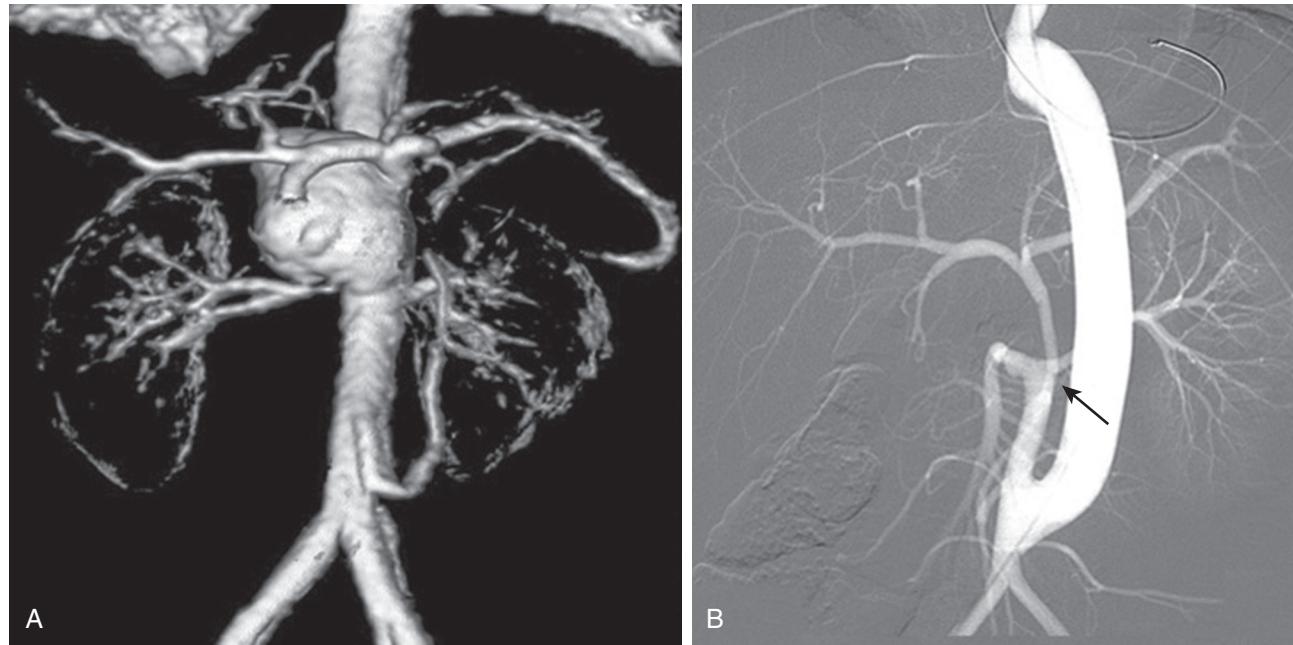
(A) Central abdominal aortic aneurysm with involvement of the celiac, superior mesenteric, and renal arteries associated with tuberous sclerosis in a 5-year-old (computed tomography angiography). (B) Treatment included aneurysmectomy, 14-mm expanded polytetrafluoroethylene thoracoabdominal bypass, aortic reimplantation of a left renal artery and superior mesenteric artery (SMA), and aortoceliac bypass with a hypogastric artery graft, all from the distal abdominal aorta (arrow), as well as a right nephrectomy (digital subtraction arteriography). (From Eliason JL, Coleman DM, Criado E, Stanley JC. Surgical treatment of abdominal aortic aneurysms in infancy and early childhood. *J Vasc Surg*. 2016;64:1252–1261.)
